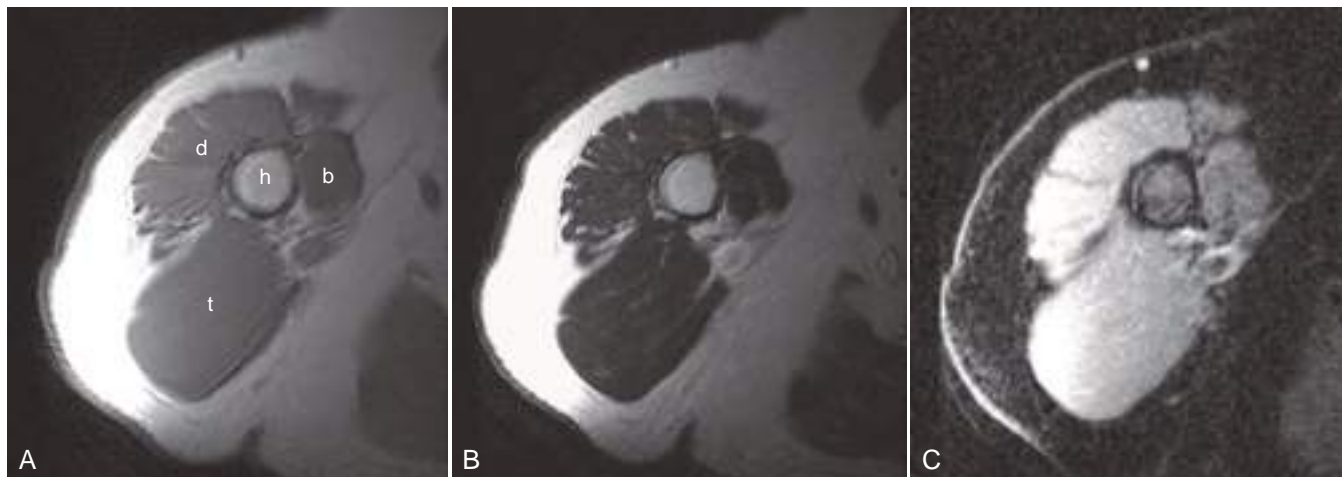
Normal muscle and fat. (A–C) Axial MR images obtained through the proximal right arm. T1-weighted (A), T2-weighted (B), and inversion recovery (C) images. Note intermediate signal intensity of muscle on all sequences. Fat is much brighter than muscle, except on the inversion recovery sequence (C), which uses an inversion time of 140 msec at 1.5 T to null fat signal. A selective presaturation pulse can accomplish the same effect. Inversion recovery using a shorter inversion time of 110–130 msec suppresses but does not eliminate fat signal, resulting in images that many radiologists find easier to interpret. Most of the inversion recovery images in this text use a shorter inversion time. The fat signal intensity in A and B and muscle signal in C artifactually much higher laterally because of proximity to the receiver coil. b, Biceps; d, deltoid; h, humerus; t, triceps.
